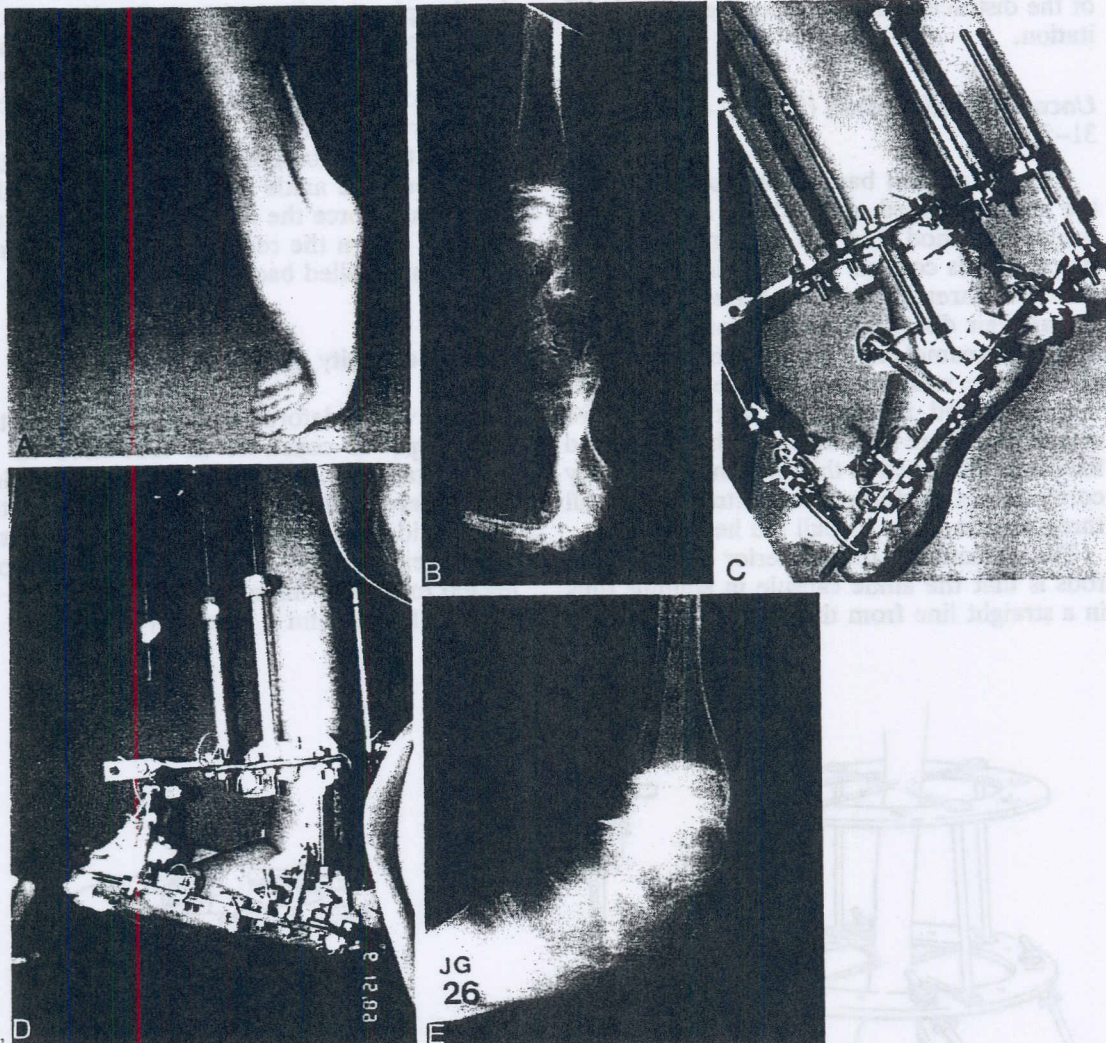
(A and B), Lateral photograph and radiograph of the ankle before correction. (C and D), The apparatus is shown from the lateral view during correction and at the end of overcorrection. Note that in this example, a wire was inserted across the axis of rotation of the ankle joint and connected to the hinges. This is another modification of the constrained technique. (E), The lateral radiograph after correction. (Courtesy of Dror Paley, M.D.)
